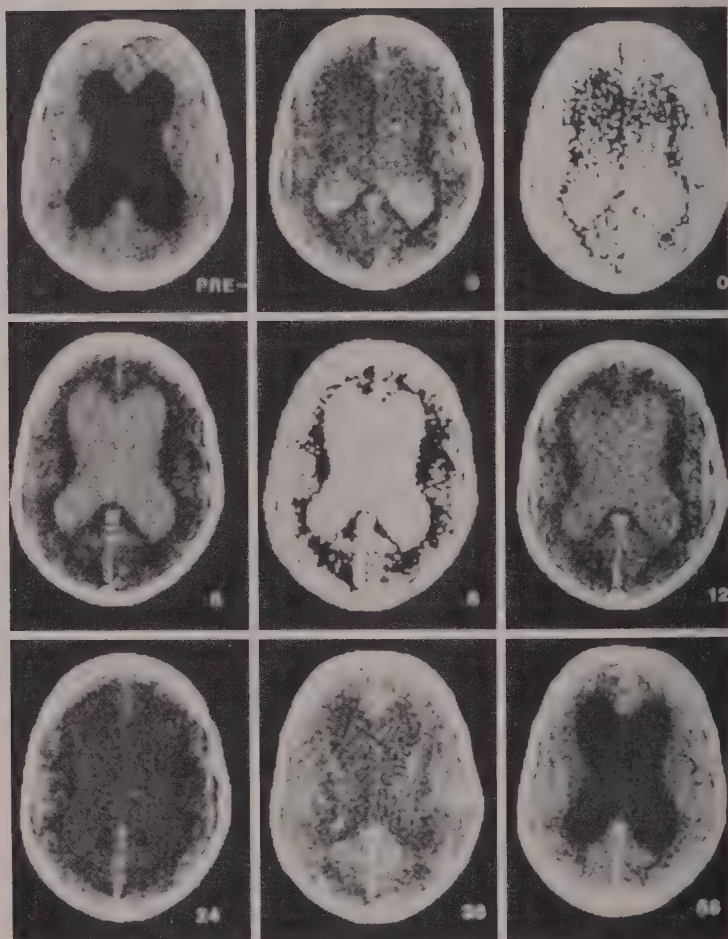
Metrizamide CT Cisternography. Abnormal Cerebrospinal Fluid Dynamics. PRE, Preliminary NCT reveals large, bilaterally symmetric lateral ventricles, but normal cortical sulci. The ventricular margin is slightly irregular.
